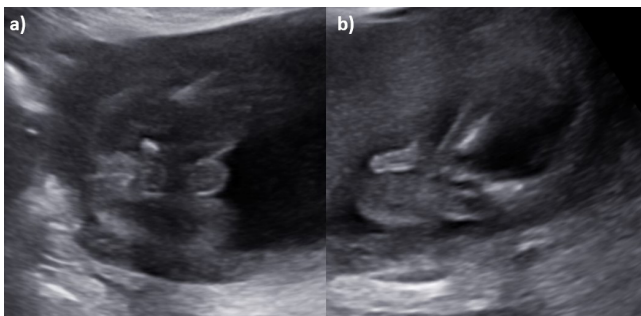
Coronal sonogram of the pelvis showing a) a scrotal sac without an identifiable penis and b) a phallic protrusion extending dorso-caudally from the scrotum to the anal orifice. This finding may indicate an abnormality in genital development, such as in cases of penoscrotal transposition or other congenital anomalies
